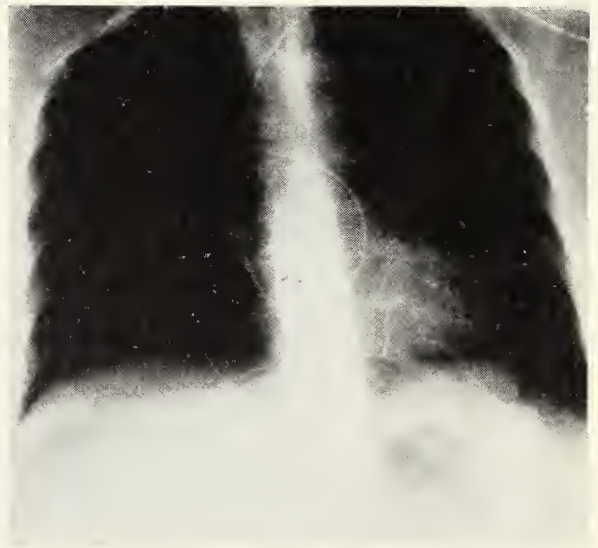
Supine, anteroposterior, overpenetrated chest x-ray demonstrating the position of a catheter in the pulmonary artery.
